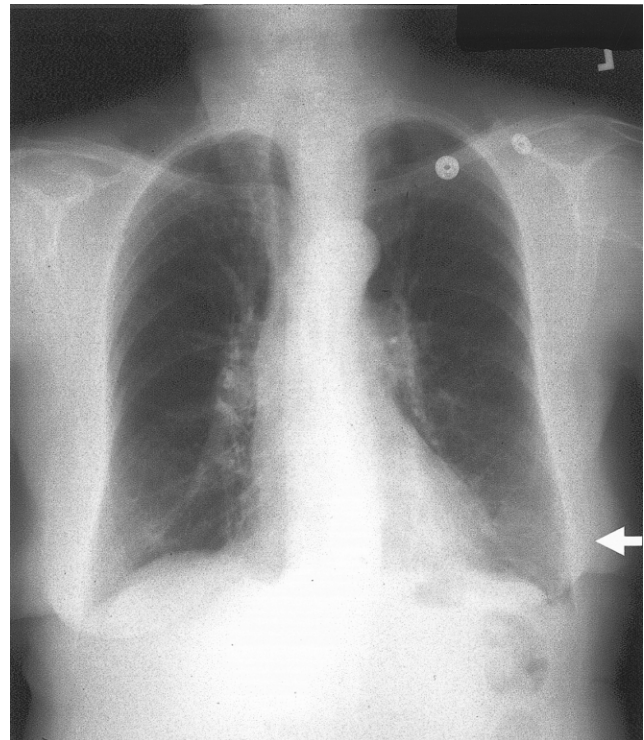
Representative chest radiograph from a study subject. The arrow indicates the location of the radiographic findings. The official reading was left basilar atelectasis vs. pneumonia in an 82-year-old male with steroid-dependent asthma, hypertension, and atrial fibrillation. Influenza was diagnosed by serologic testing.
